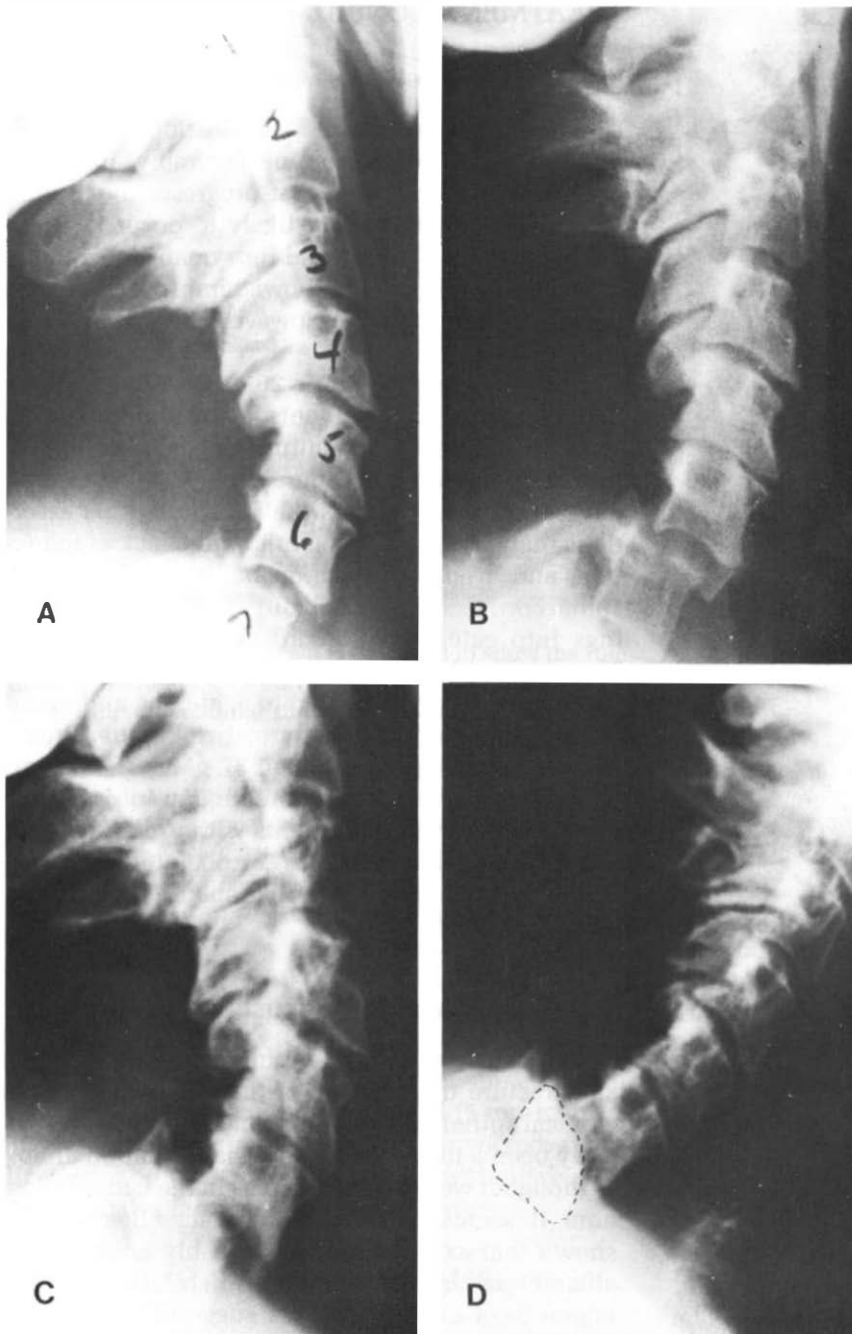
These radiographs demonstrate several important points about the problem of clinical stability. Laminectomy and facetectomy that include all the posterioelements render the spine clinically unstable; the subsequent disruption of the anterior elements in order to insert a bone graft makes the situation even more grossly unstable. The two components of instability, translatory, shown in B and C, and rotatory, shown in D, are graphically demonstrated by this case. (Courtesy of W. O. Southwick, M.D.)
